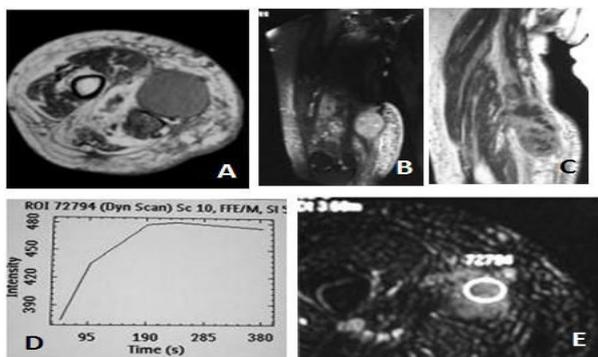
62-year-old woman with a undifferentiated pleomorphic sarcoma. Axial T2-W TSE image (A) demonstrates ~4 cm heterogeneous, hyperintense mass relative to that of muscle in the upper part of the right leg. Coronal STIR image (B) depicts peritumoral edema. Coronal static contrast-enhanced T1-weighted MR image (C) shows peripheral enhancement. Type 2 time-signal intensity curve (D) generated by using ROI on dynamic contrast-enhanced images (E).
